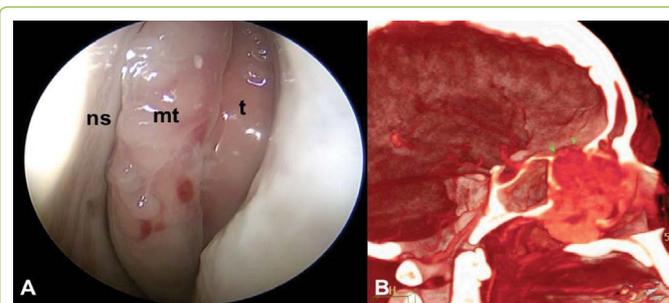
A: endoscopic view of the tumor situated laterally of middle turbinate occupying middle meatus. B: 3D CT scan reconstruction showed the markedly vascularized tumor and the limited anterior cranial base invasion (green arrows). mt: middle turbinate; ns: nasal septum; t: tumor.
